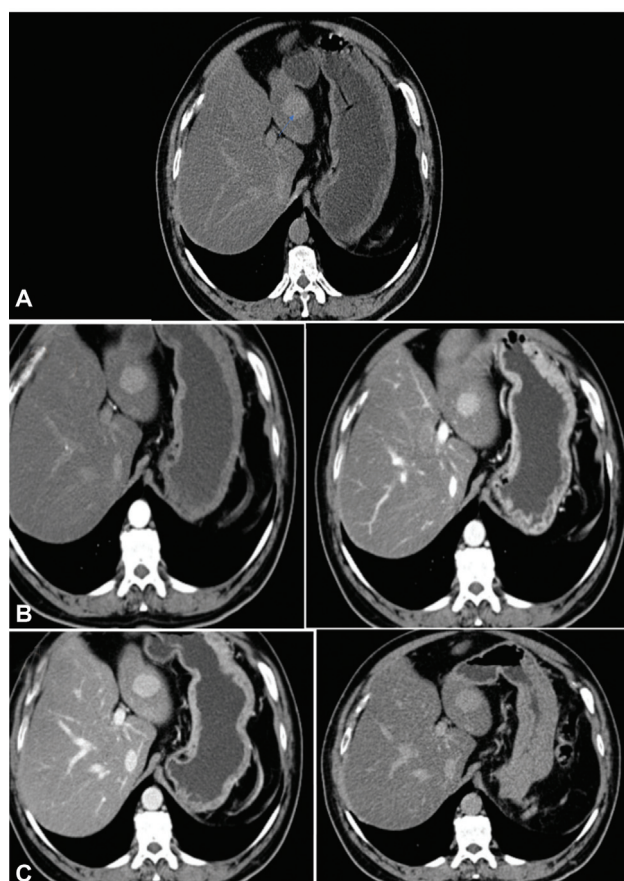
(A) The axial non-contrast CT section revealing diffuse hypoattenuation of the hepatic parenchyma with a relatively dense space-occupying lesion in the left lobe of the liver (arrow). (B and C) Contrast-enhanced CT axial sections—arterial and portal phase images—reveal arterial and portal phase-enhancing lesions in the left lobe of the liver (B). Persistent enhancement of the lesion in the venous phase and delayed phase (C) compared to hepatic parenchyma.
